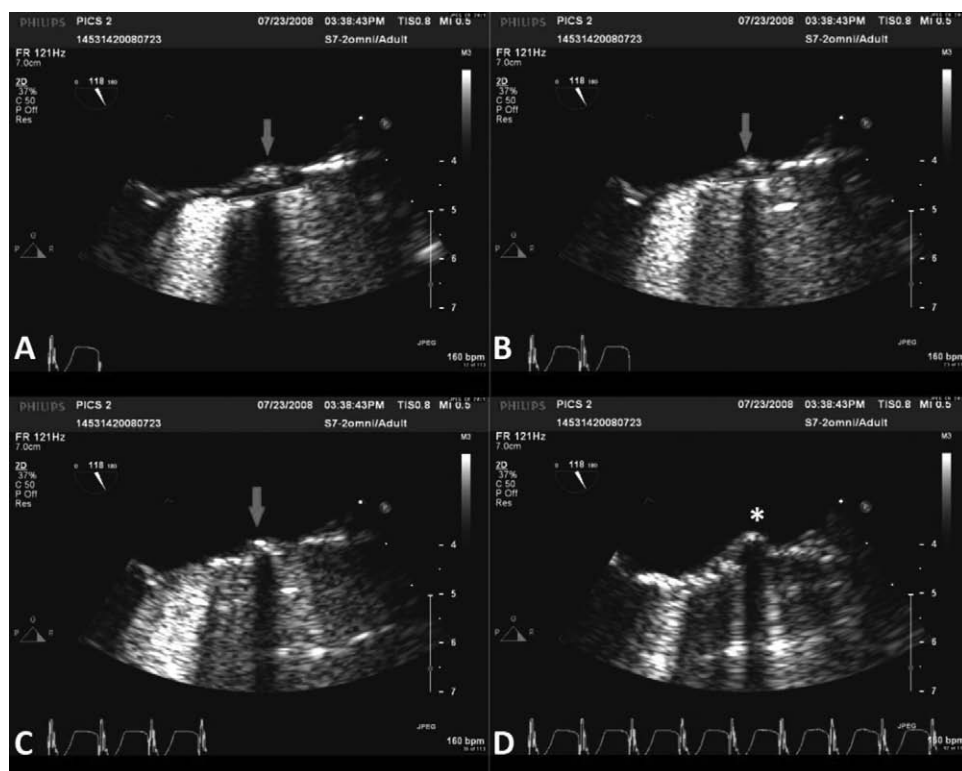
Intraoperative transesophageal echocardiogram sequences obtained during an Edwards-SAPIEN valve deployment (A through C). D, The deployment resulted in perforation (*) of the sinus of Valsalva by a heavily calcified aortic valve cusp leaflet (red arrow) folded up toward the sinus wall by the stent (red line).
